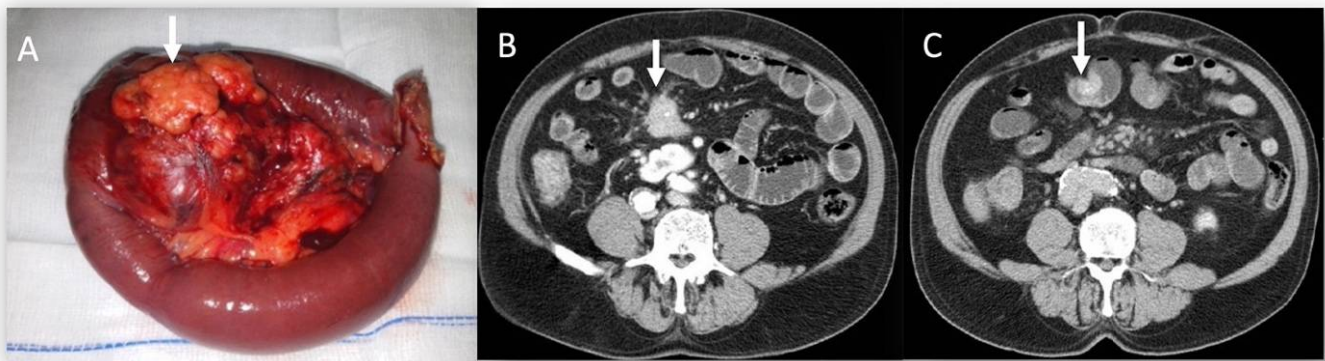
Sample size (A) of small bowel NEN with desmoplastic reaction (arrows in (A) and (B)), evaluated on CT (B) in portal phase of contrast study. In (C), arrow shows the intraluminal small tumor as an enhanced polypoid lesion.
